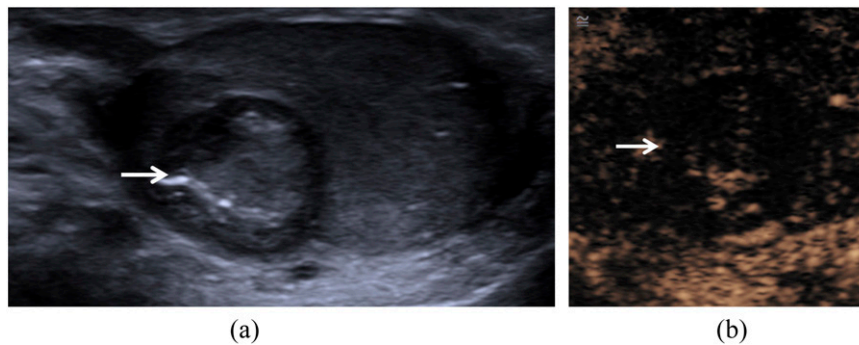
A 15-year-old male with incidentally found testicular lesion: B-mode ultrasonography (a) is showing a rounded isoechoic lesion (arrow) with a hypoechoic halo and central hyperechoic parts. Contrast-enhanced ultrasound (b) is showing limited internal echoes excluding the presence of a malignant tumour and establishing the diagnosis of an epidermoid tumour (arrow).
